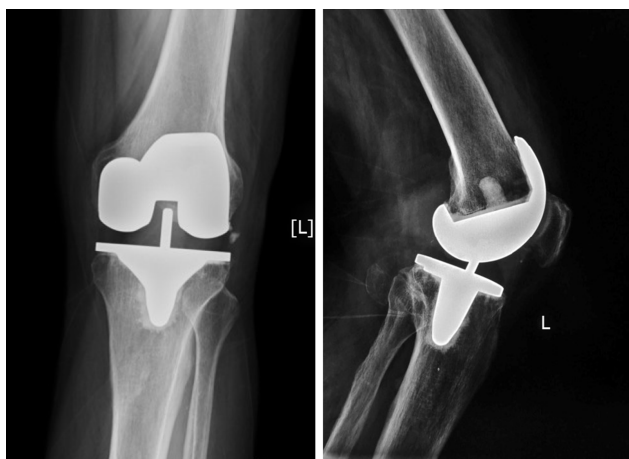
Radiography showed excellent alignment and no prosthetic loosening.
